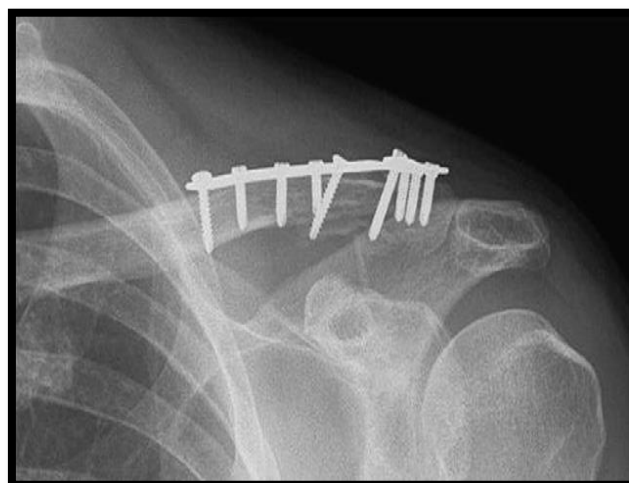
Postoperative X-ray type II distal clavicular fracture
